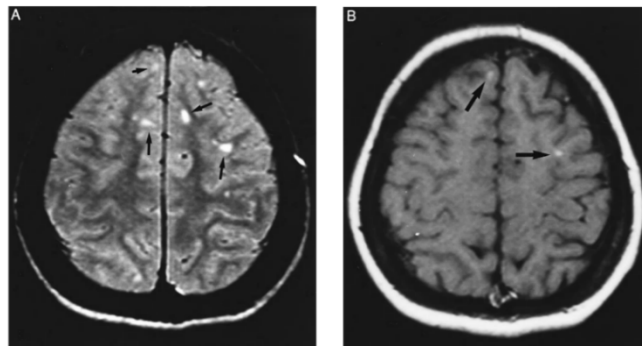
Magnetic resonance imaging (MRI) scan of a patient diagnosed with clinically definite multiple sclerosis. Note lesions in the frontal and parietal lobes (A) and lesions within the cortex (B) indicate areas of demyelination. (28). *Images from Barkhof F., et al., 1997, Brain.*
